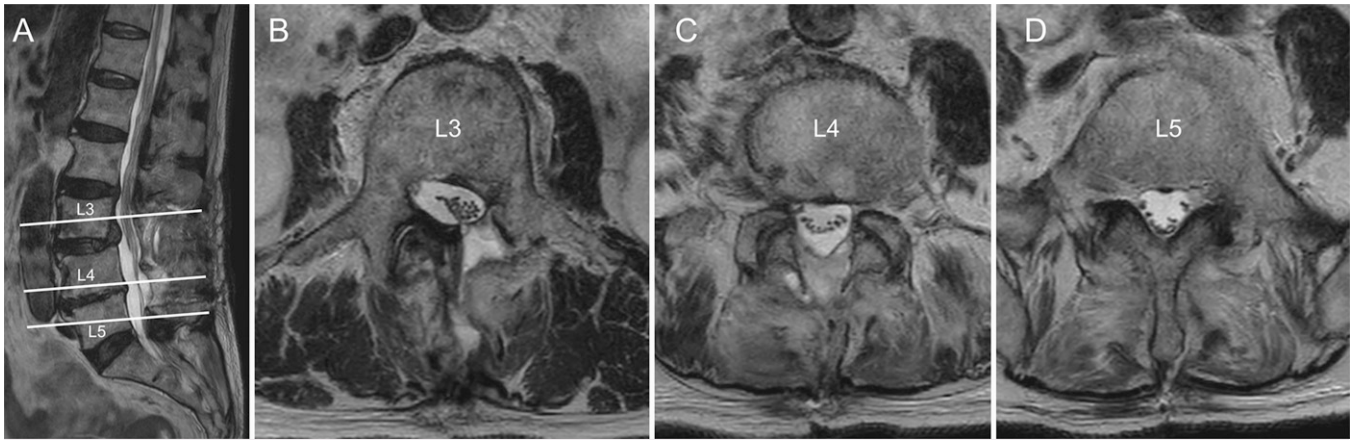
Two-week postoperative sagittal T2-weighted (A) and axial (levels of the white lines in panel A) T2-weighted (B–D) MRI shows improved spinal nerves that are deviated to the ventral side by SSEH.
